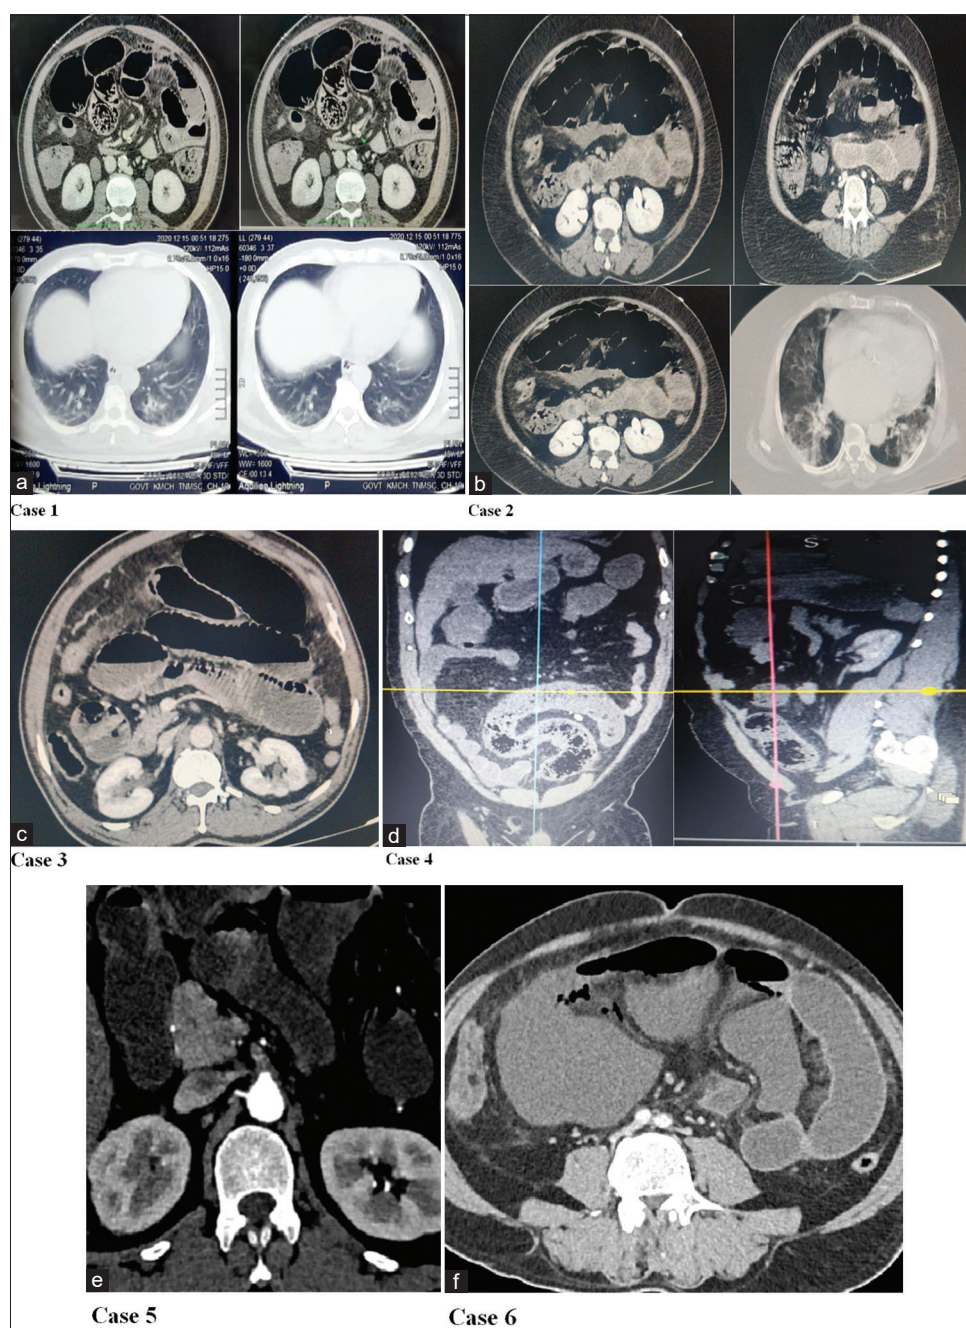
Radiological findings in Cases 1–6. (a) Case 1: Contrast-enhanced computed tomography (CT) abdomen showing superior mesenteric artery (SMA) thrombosis with pneumatosis intestinalis involving the jejunal and ileal loops. (b) Case 2: Contrast-enhanced CT abdomen showing SMA thrombosis with jejunal pneumatosis and associated splenic infarction due to splenic artery thrombosis. (c) Case 3: Contrast-enhanced CT abdomen showing dilated jejunal and proximal ileal loops, reduced distal ileal mural enhancement, bowel-wall thickening and mesenteric edema, without demonstrable major mesenteric arterial thrombosis. (d) Case 4: Contrast-enhanced CT abdomen showing pneumatosis coli and ischemic changes involving the sigmoid colon, with suspected partial inferior mesenteric artery thrombosis. (e) Case 5: Contrast-enhanced CT abdomen showing SMA thrombosis, reduced small-bowel mural enhancement, pneumatosis intestinalis, and portal venous gas. (f) Case 6: CT abdomen showing free intraperitoneal air consistent with pneumoperitoneum, with distal ileal ischemic changes and no demonstrable major mesenteric arterial thrombosis
